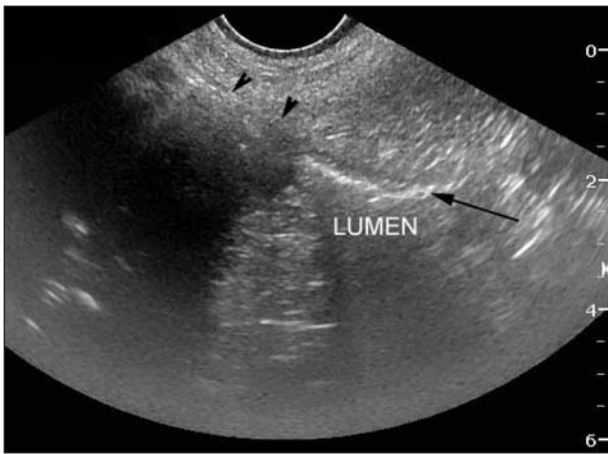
Abdominal ultrasonographic image of the mineralized mass. Notice the distal acoustic shadowing of the large mineralized mass (arrowheads) that is continuous with the intestinal wall (arrow).
